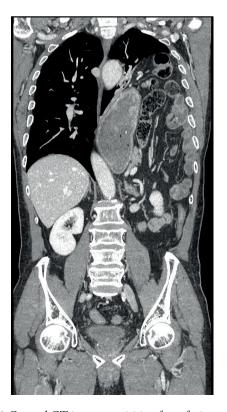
Coronal CT image acquisition for soft tissue.
